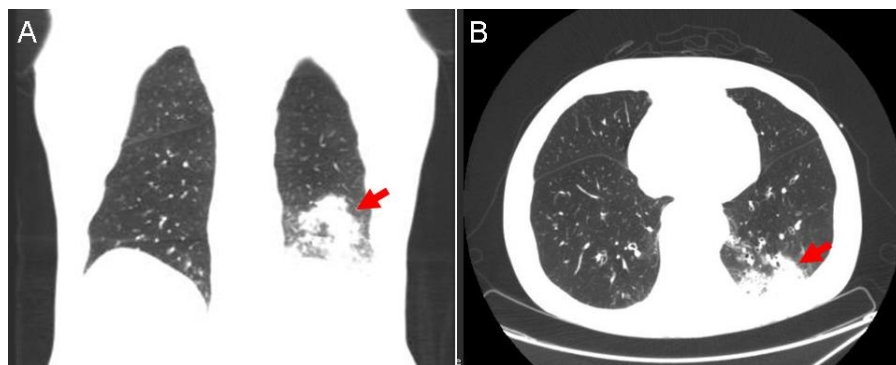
Representative images from his thoracic CT scan showing a left lower lobe consolidation (red arrows). Panel A: coronal projection in lung windows. Panel B: axial view in lung windows.
